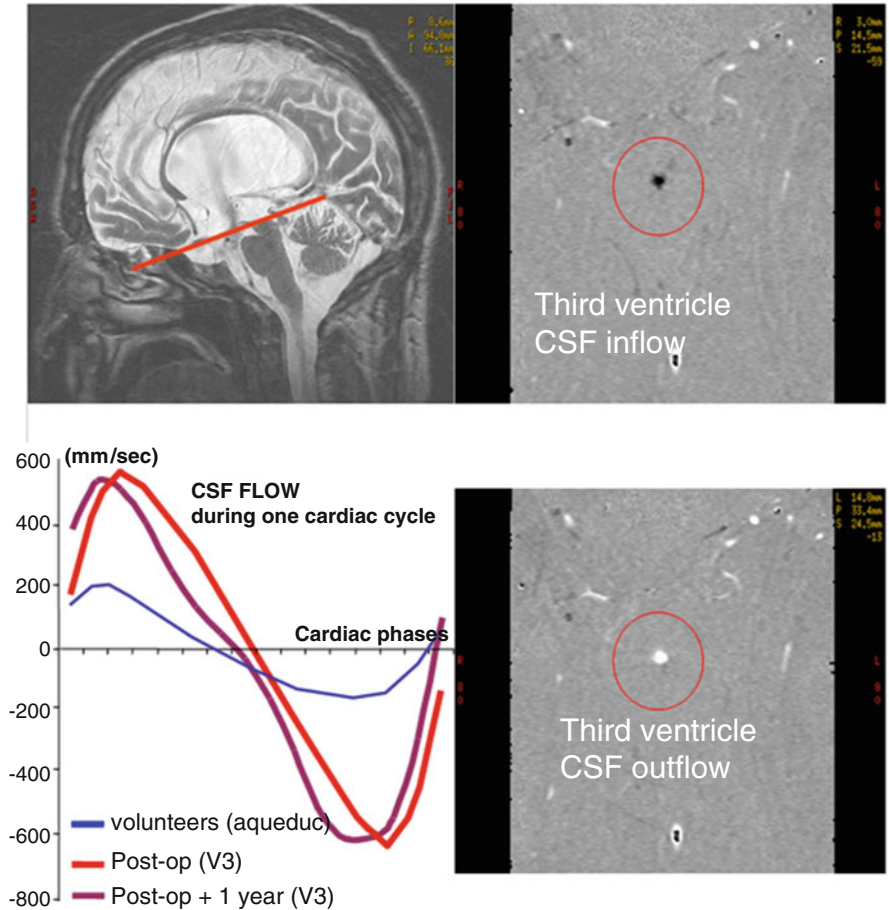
Example of noncommunicating hydrocephalus studied using PC-MRI examination. The patient had aqueductal stenosis, detected by PC-MRI and treated by ETV. PC-MRI was performed 3 months after surgery to confirm the aperture of the third ventricle. In comparison with volunteer curve flow (in blue), we can see that CSF flow in the third ventricle aperture has the same temporal evolution, whereas its amplitude is increased. This difference can be due to the third ventricle aperture flow resistance which is smaller than in normal aqueduct. One year later, PC-MRI in the same patient showed a similar CSF flow curve at the third ventricle aperture
